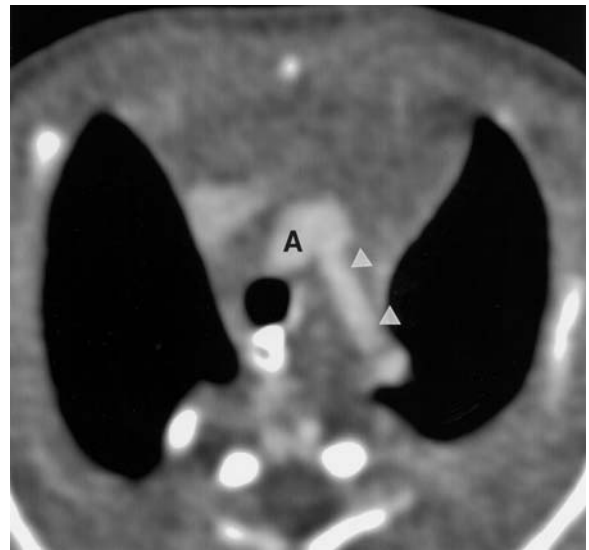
Interrupted aortic arch. A: Axial CT section in a 2 kg neonate demonstrates a normal caliber proximal aorta (A). The vessel latter and inferior to the aorta is a dilated patent ductus arteriosus (arrowheads). B: Volume-rendered reconstruction shows a markedly hypoplastic transverse arch (arrowhead) and a large patent ductus arteriosus (PDA) which supplies the distal aorta
